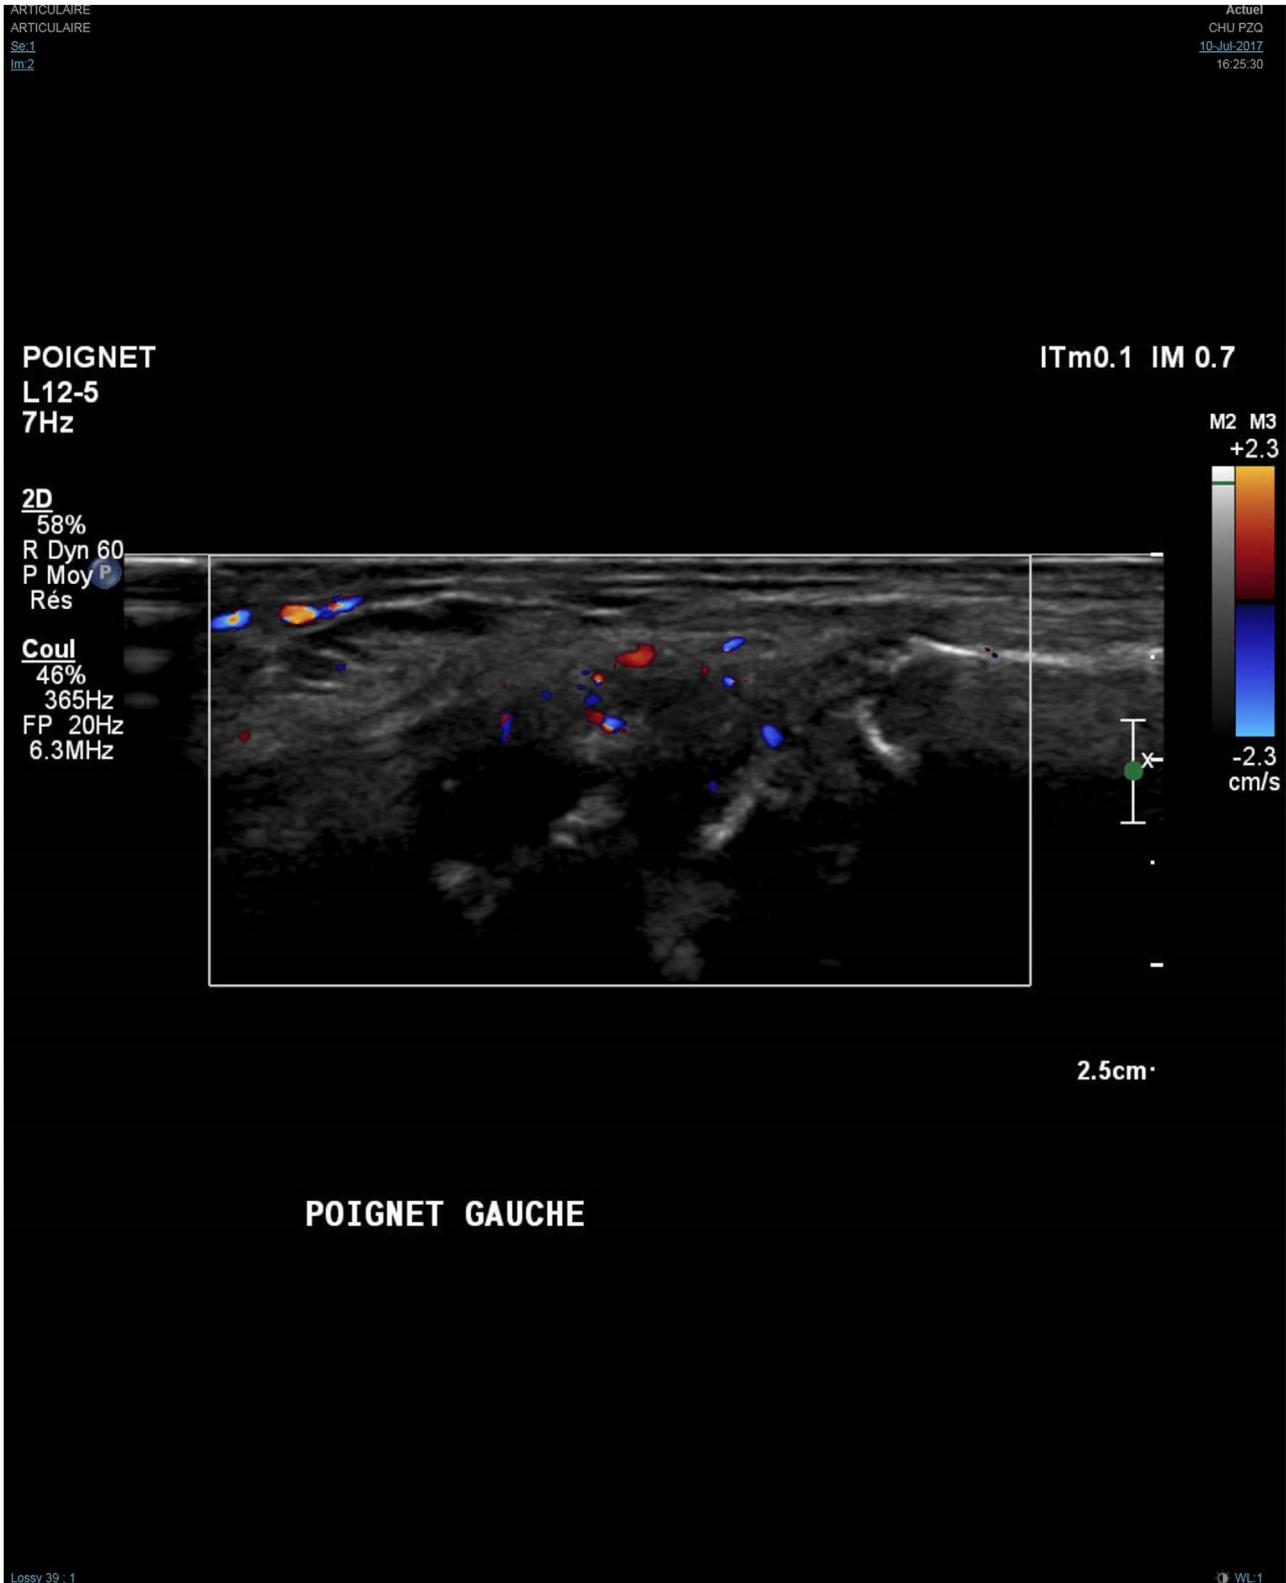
Doppler ultrasound examination of a left wrist. Presence of synovitis, with effusion and positive Doppler effect (grade 2, Szkudlarek' classification).
